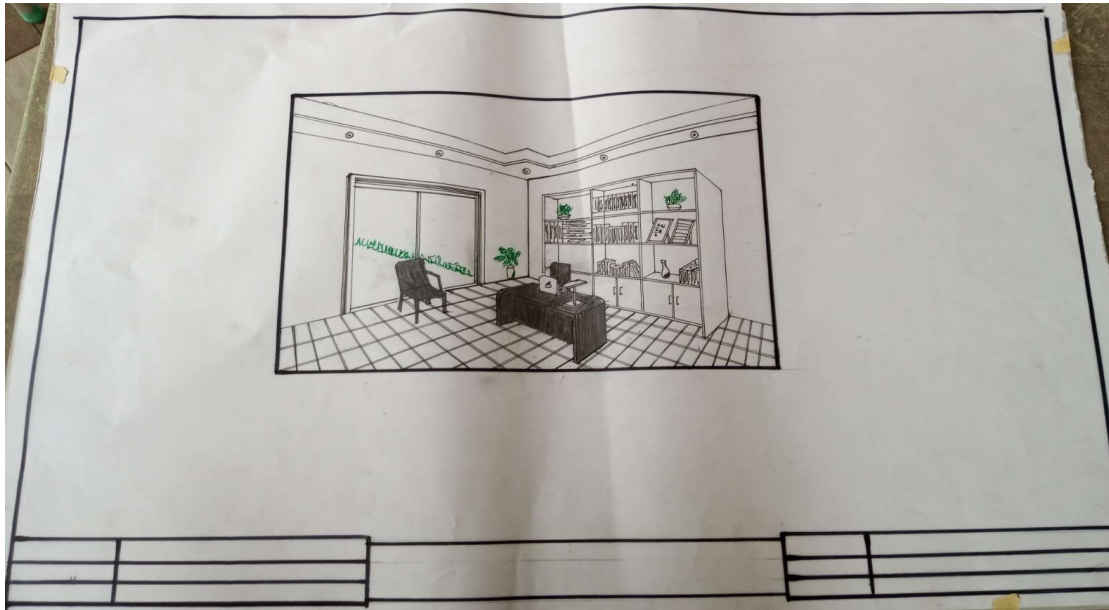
INNER PERSPECTIVE
